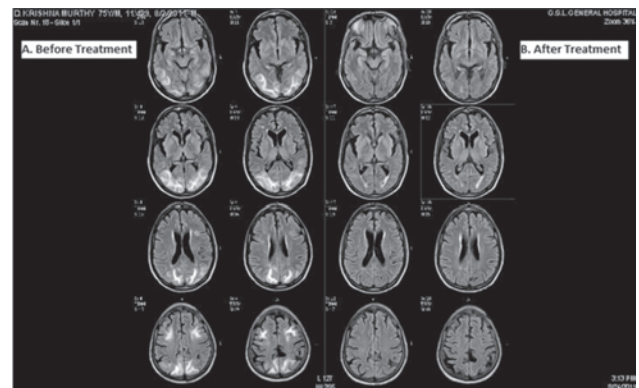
Comparative axial T2 FLAIR images before (A) and after (B) treatment showing significant radiological improvement with almost complete disappearance of lesions.
